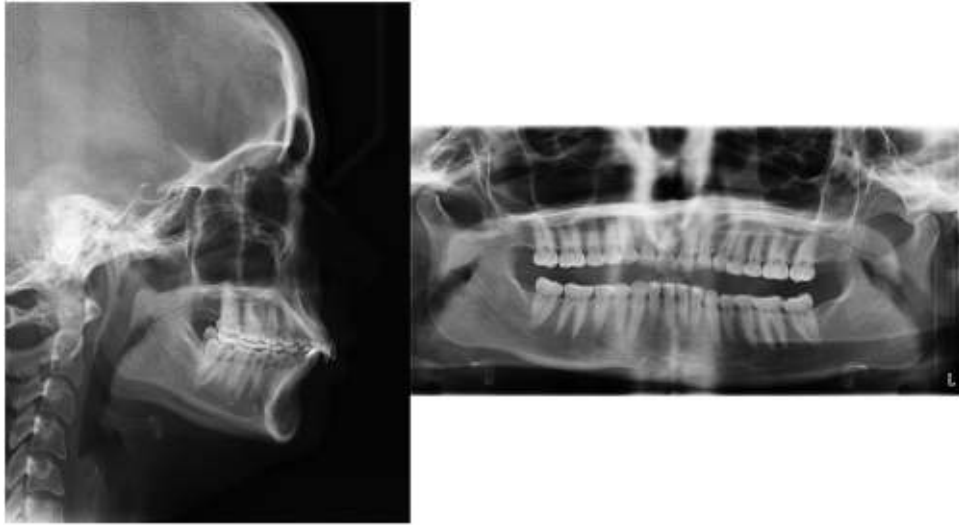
Initial lateral cephalograph and orthopantomograph radiograph.
